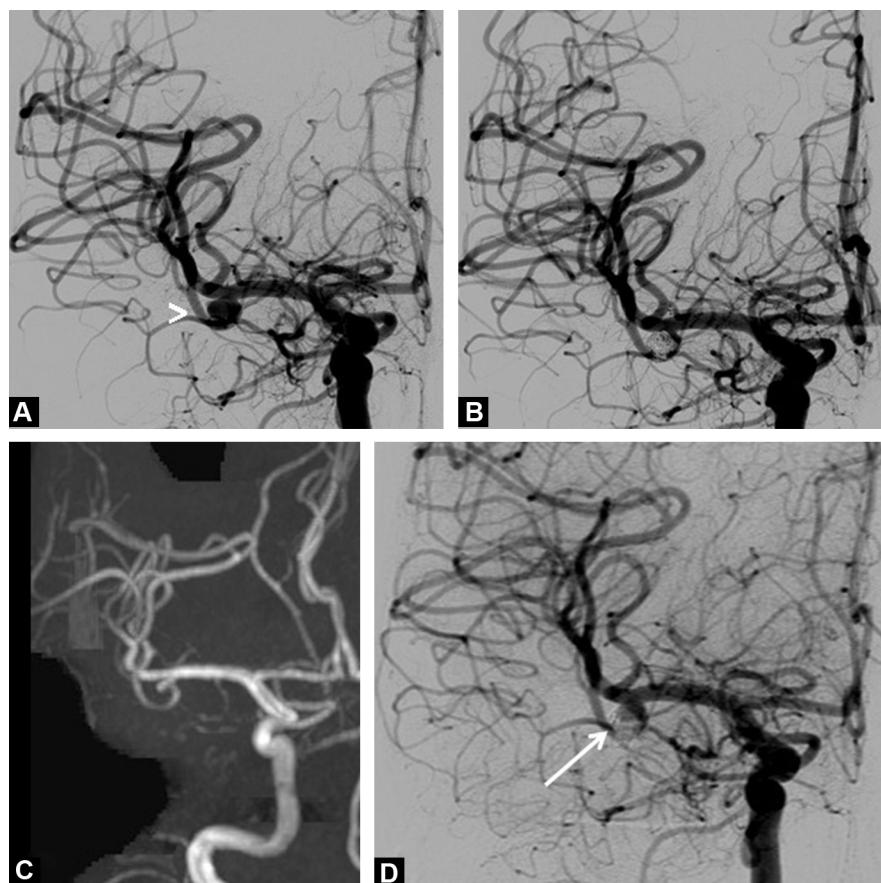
Forty-seven year old woman with a past history of subarachnoid hemorrhage due to rupture of an aneurysm of an inferior dividing branch of the right middle cerebral artery (A, arteriography, arrowhead) with complete exclusion after coiling (B). Residual aneurysm seen at 6 months on time of flight MRI (C) and cerebral arteriography (D, arrow).
